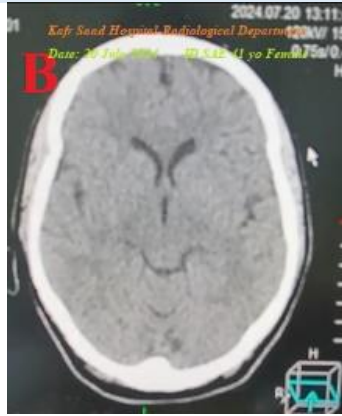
There is no laboratory hypocalcemia. Brain CT was normal
